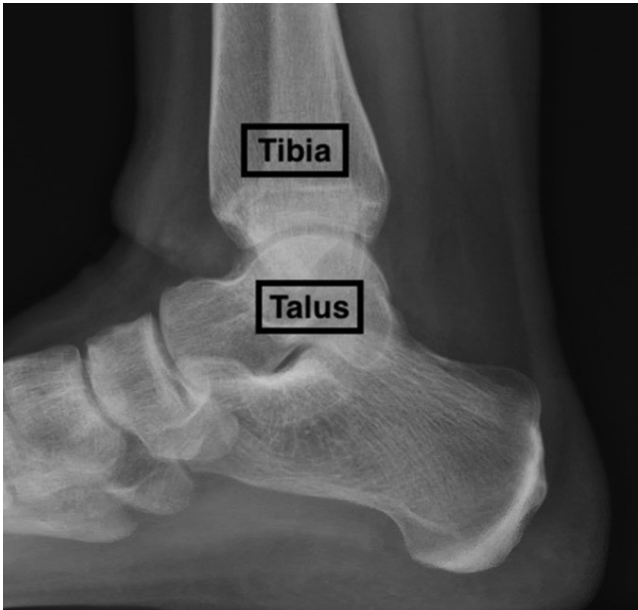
Lateral radiographic view of left ankle.
